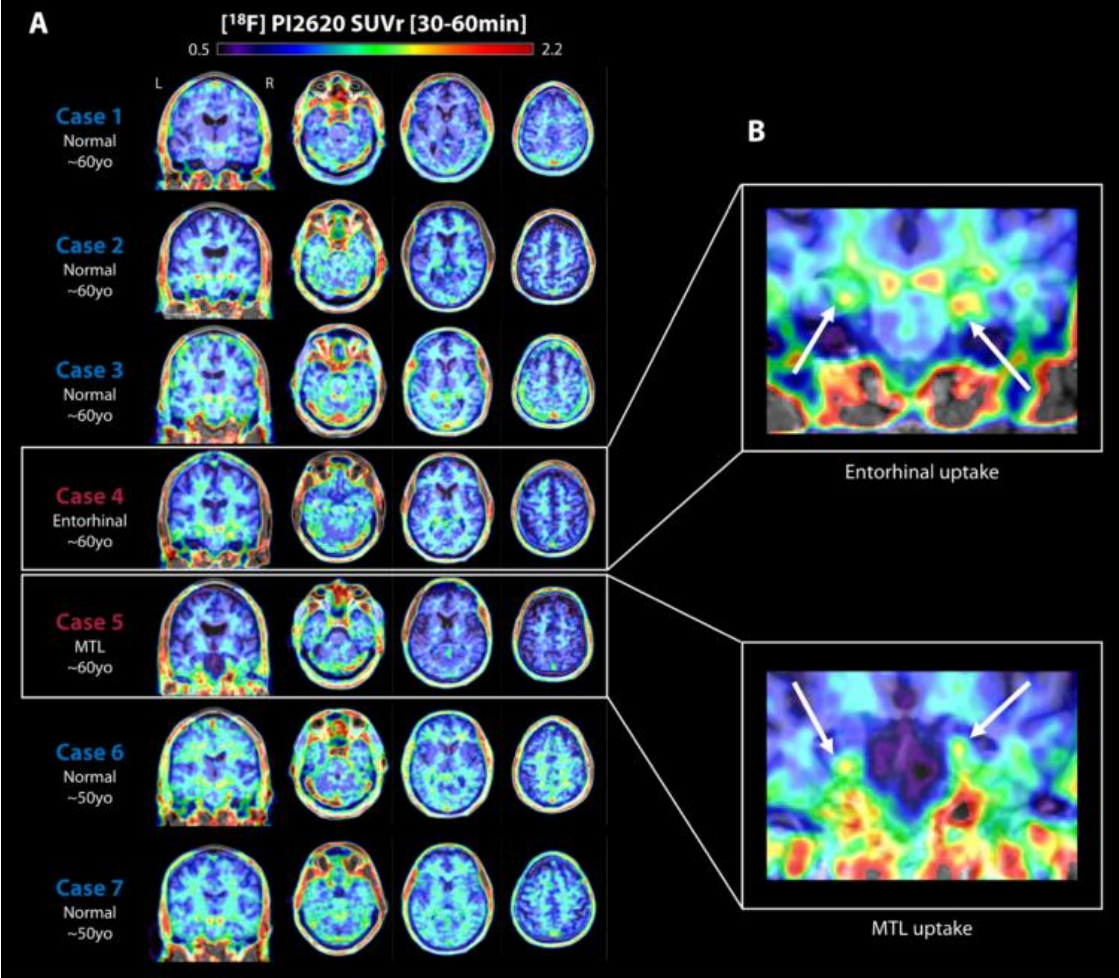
[¹⁸F]PI-2620 SUVR scans in seven American football players with TES-CTE.
